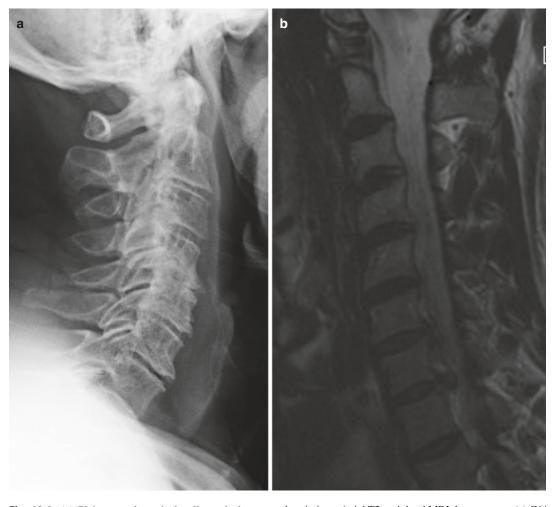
(a) Plain neutral cervical radiograph demonstrates degenerative changes from C3 to C7 and loss of disc height at multiple levels. (b) Sagittal T2-weighted MRI demonstrates congenital stenosis with two large disc
